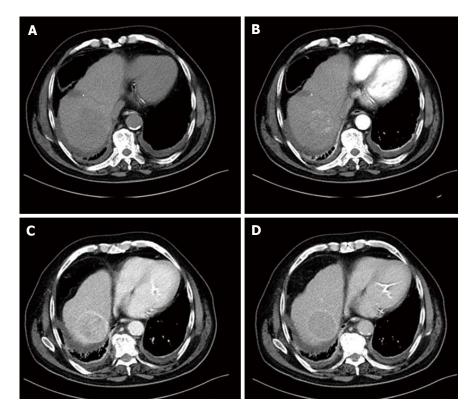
Multiphasic computed tomography in a large hepatocellular carcinoma located in the right liver lobe. A: Unenhanced image; B: Lesion's enhancement in the late hepatic arterial phase; C: Lesion's "washout" in the portal venous phase; D: Delayed phase image. The lesion has capsule appearance most shown in the portal venous and delayed phase.
